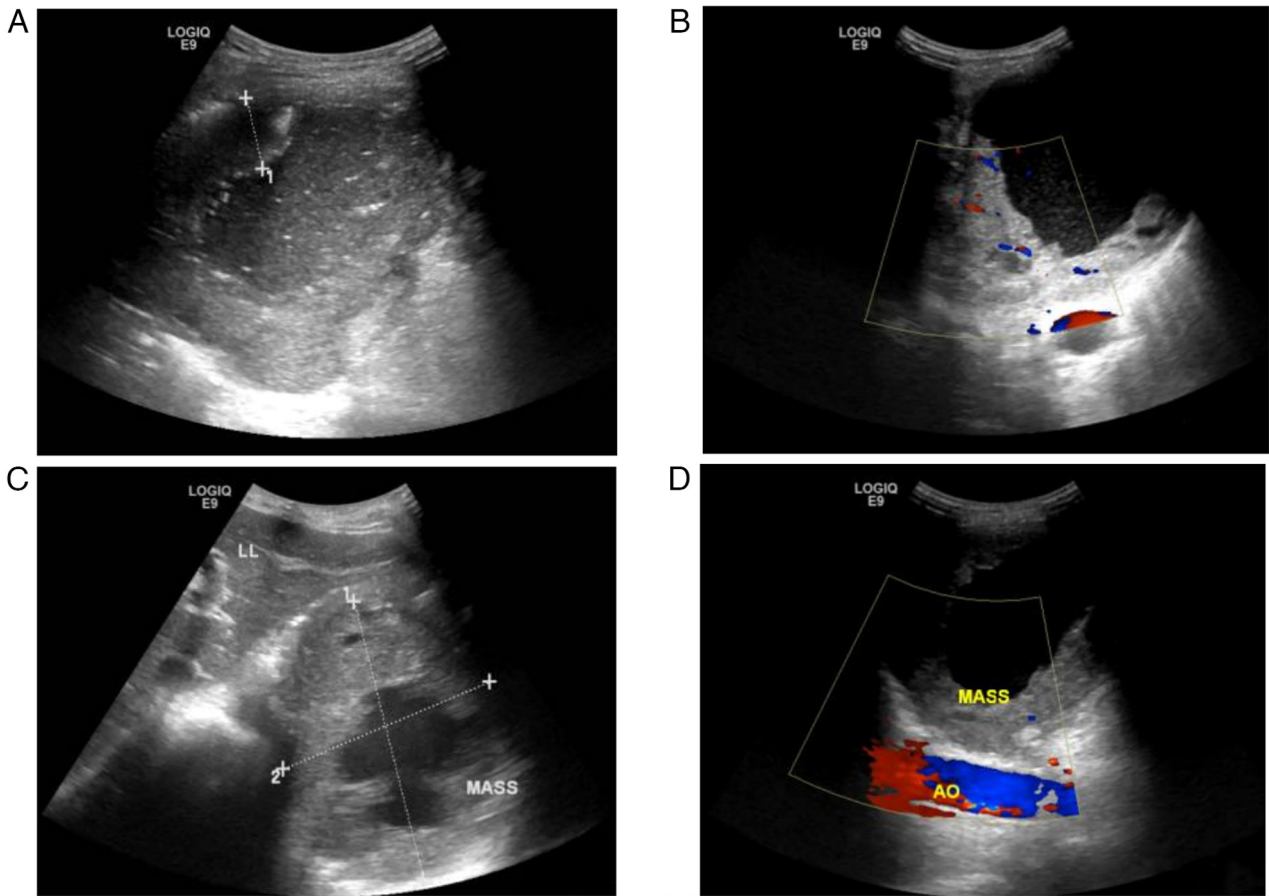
Ultrasonographic findings. (A) Ultrasonography detected a heterogeneous echo mass in the residual spleen under the left diaphragm with thick hypoechoic peripheral wall. (B) Color Doppler ultrasonography demonstrated a blood flow signal. (C) An ultrasonic median longitudinal abdominal scan found that the mass was close to the left lateral lobe of the liver. (D) An ultrasonic xiphoid downward oblique scan found that the mass was anterior to the abdominal aorta. LL, left lateral lobe of the liver; AO, abdominal aorta.
